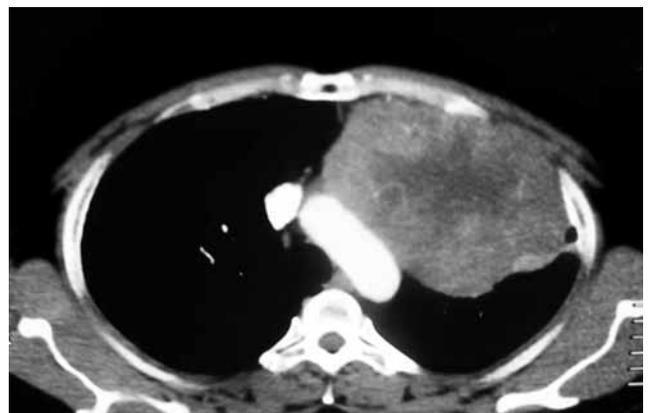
Computed tomographic scan revealing a mass anterior to the aortic arch.
